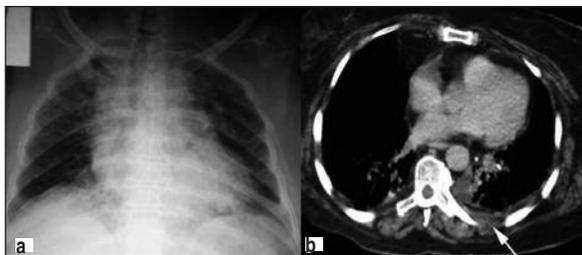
(a) The patient's chest x-ray on admission revealed fractures of 3rd, 4th, 5th, 6th ribs and minimal pleural effusion on the left side and fracture of 4th rib on the right side (b) The patient's axial thoracic CT on admission revealed pleural effusion (white arrow).
